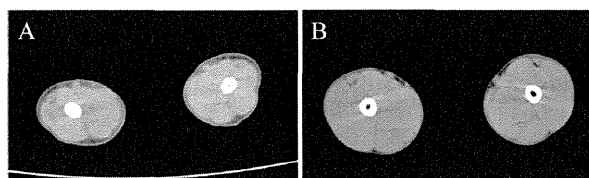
Computed tomographic scan at the thigh level at 1 year (A) and 2 years and 10 months (B) of age. The thigh muscles showed hypertrophy without abnormal intensity. Note the progressive loss of subcutaneous adipose tissues.
